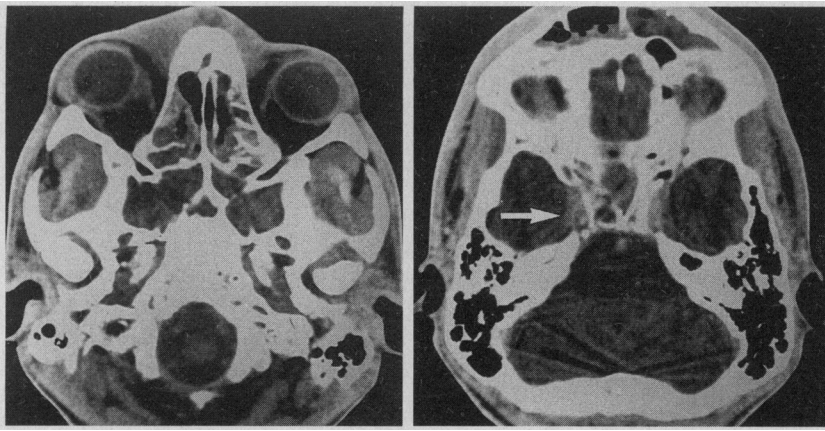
Left, Axial computed tomographic scan of the brain (April 10, 1989) shows regression of the right-sided facial and orbital swelling. Right, Axial computed tomographic scan of the brain (April 10, 1989) shows recanalization (enhancement) of the cavernous sinus (arrow).
